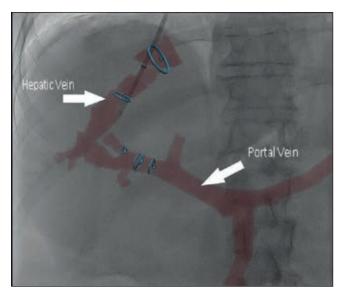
CT guided fusion imaging
